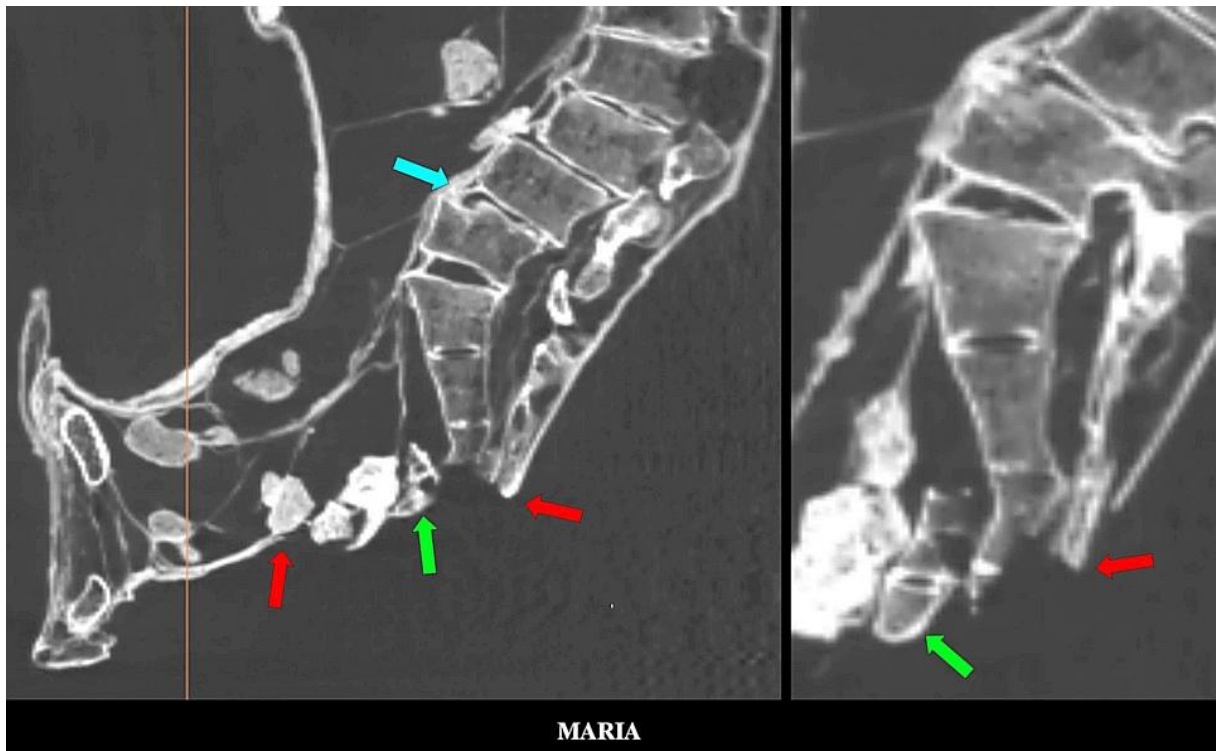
2D sagittal CT scans showing extensive defect (*red arrows*) in sacral and perineal areas. (*left*) The sacrum (*right*) was transacted at S3 level with fracture fragment (*green arrow*) located slightly more anteriorly.
